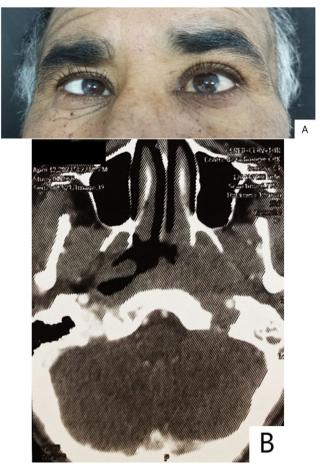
1A: Left abduction deficit. 1B: CT-scan showing a left nasopharyngeal mass.
